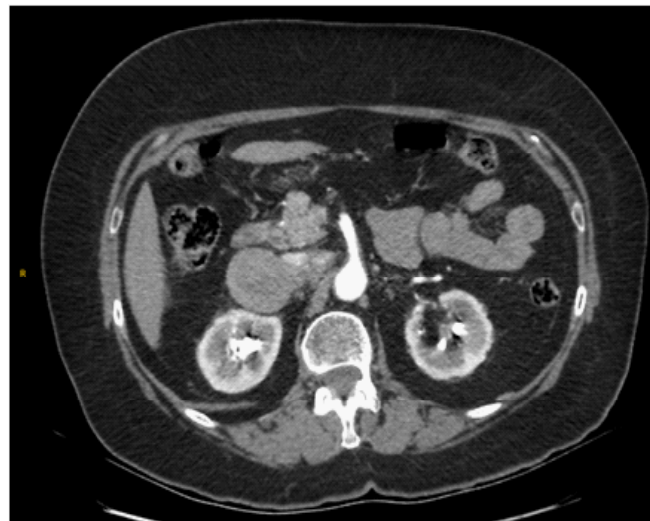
CT scan showing BIBC metastases to right adrenal gland.
